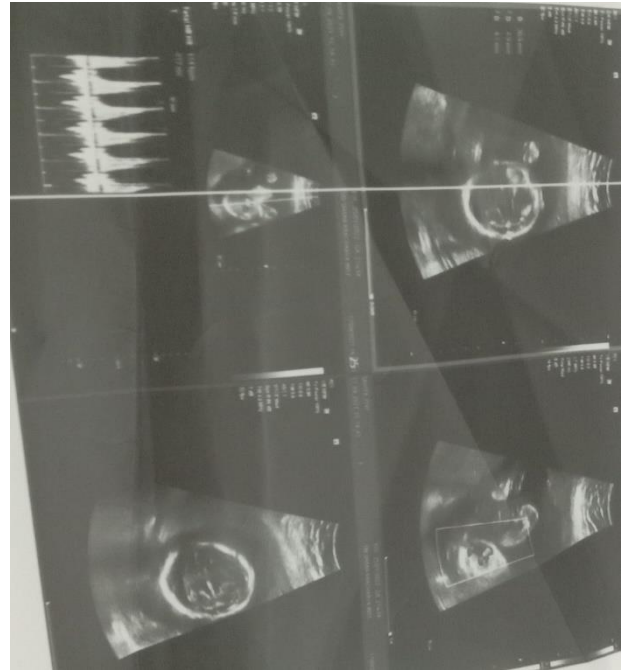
Sonography findings of intra-peritoneal collection with fetus and Doppler changes.
